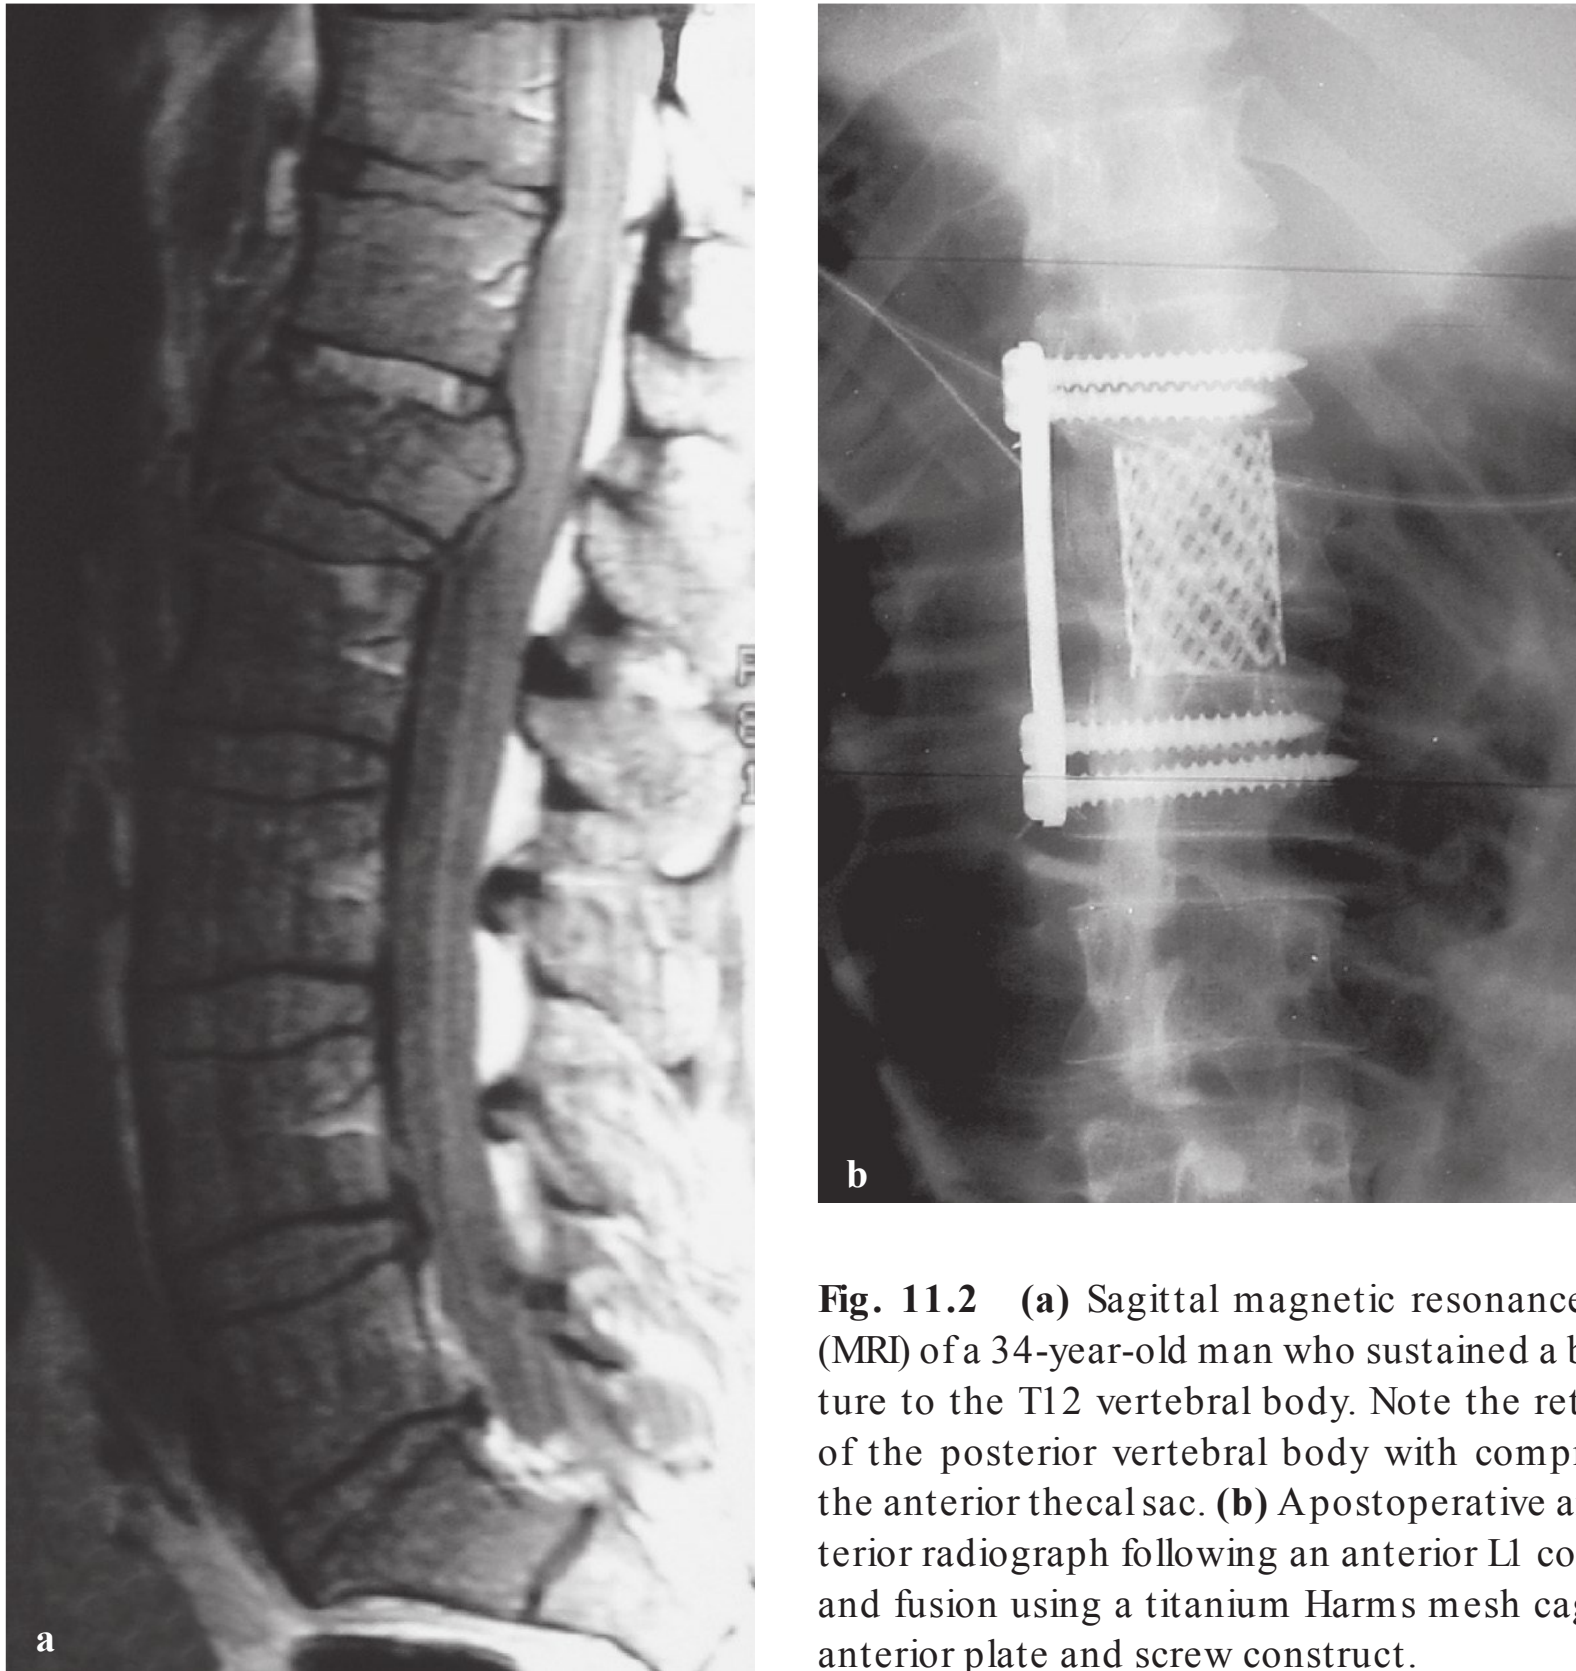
(a) Sagittal magnetic resonance imaging (MRI) of a 34-year-old man who sustained a burst fracture to the T12 vertebral body. Note the retropulsion of the posterior vertebral body with compression of the anterior thecal sac. (b) Apostoperative anteroposterior radiograph following an anterior L1 corpectomy and fusion using a titanium Harms mesh cage and an anterior plate and screw construct.
